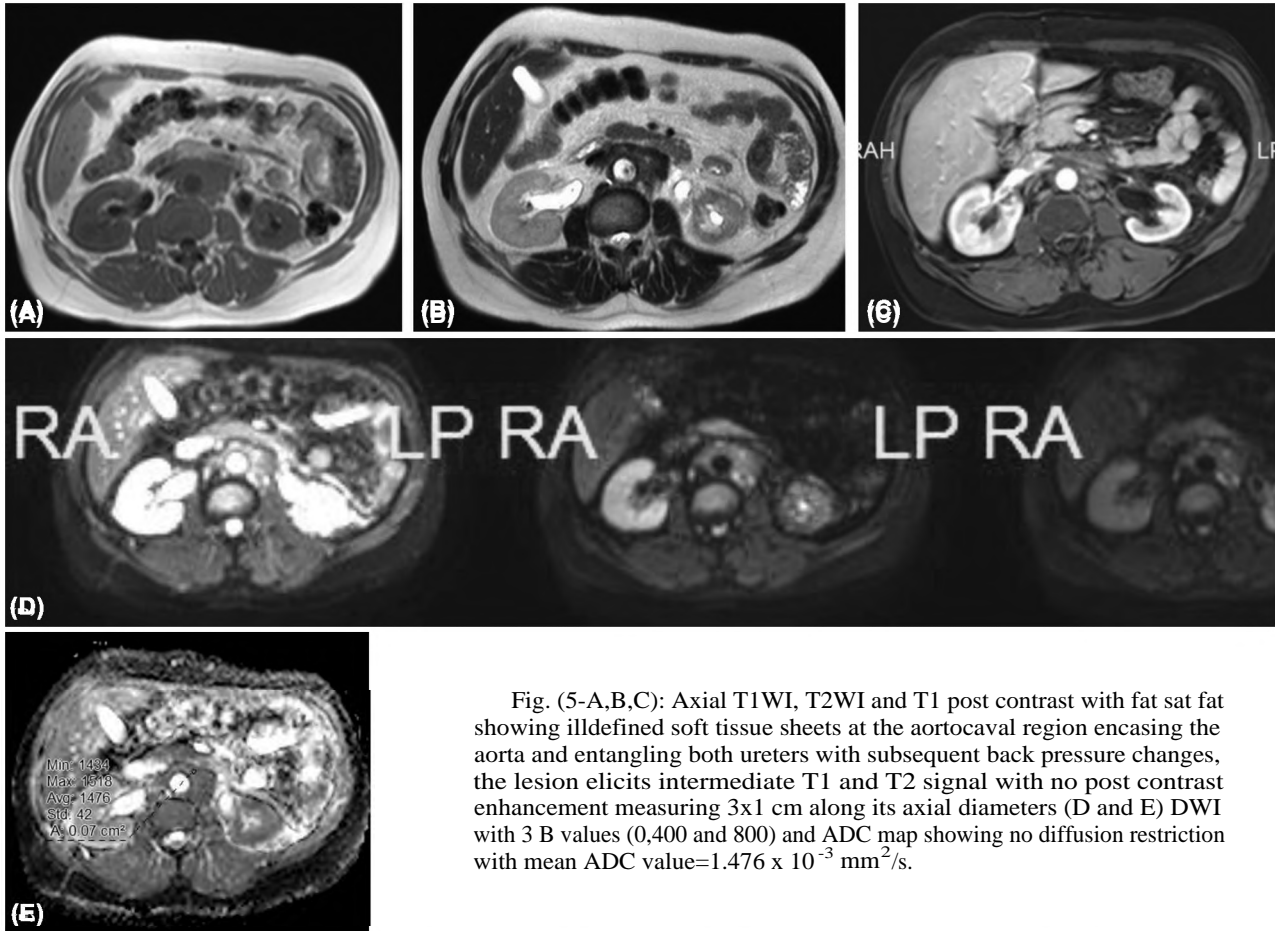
Axial T1WI, T2WI and T1 post contrast with fat sat fat showing illdefined soft tissue sheets at the aortocaval region encasing the aorta and entangling both ureters with subsequent back pressure changes, the lesion elicits intermediate T1 and T2 signal with no post contrast enhancement measuring 3x1 cm along its axial diameters (D and E) DWI with 3 B values (0,400 and 800) and ADC map showing no diffusion restriction with mean ADC value= $1.476 \times 10^{-3} \text{ mm}^2/\text{s}$.
